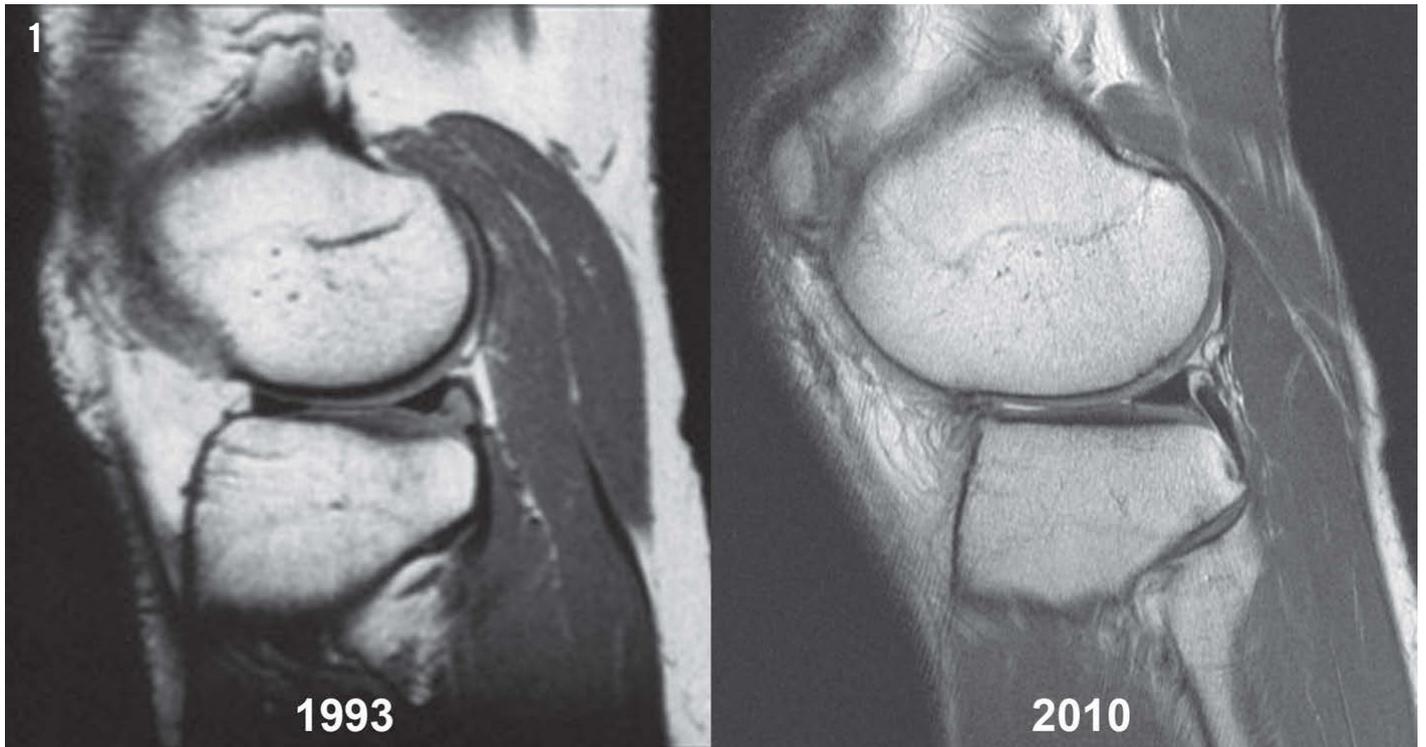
MRI of knee showing improved tissue differentiation and resolution with optimised pulse sequence. 1.5T image from 1993 is a proton density weighted spin echo sequence. 1.5T image from 2010 is a proton density weighted fast spin echo sequence using an echo time of approximately 34 m/sec for arthrographic effect. Note the improved appreciation of articular cartilage surface contour and deep chondral fissure above the posterior horn of meniscus on the more recent image.
